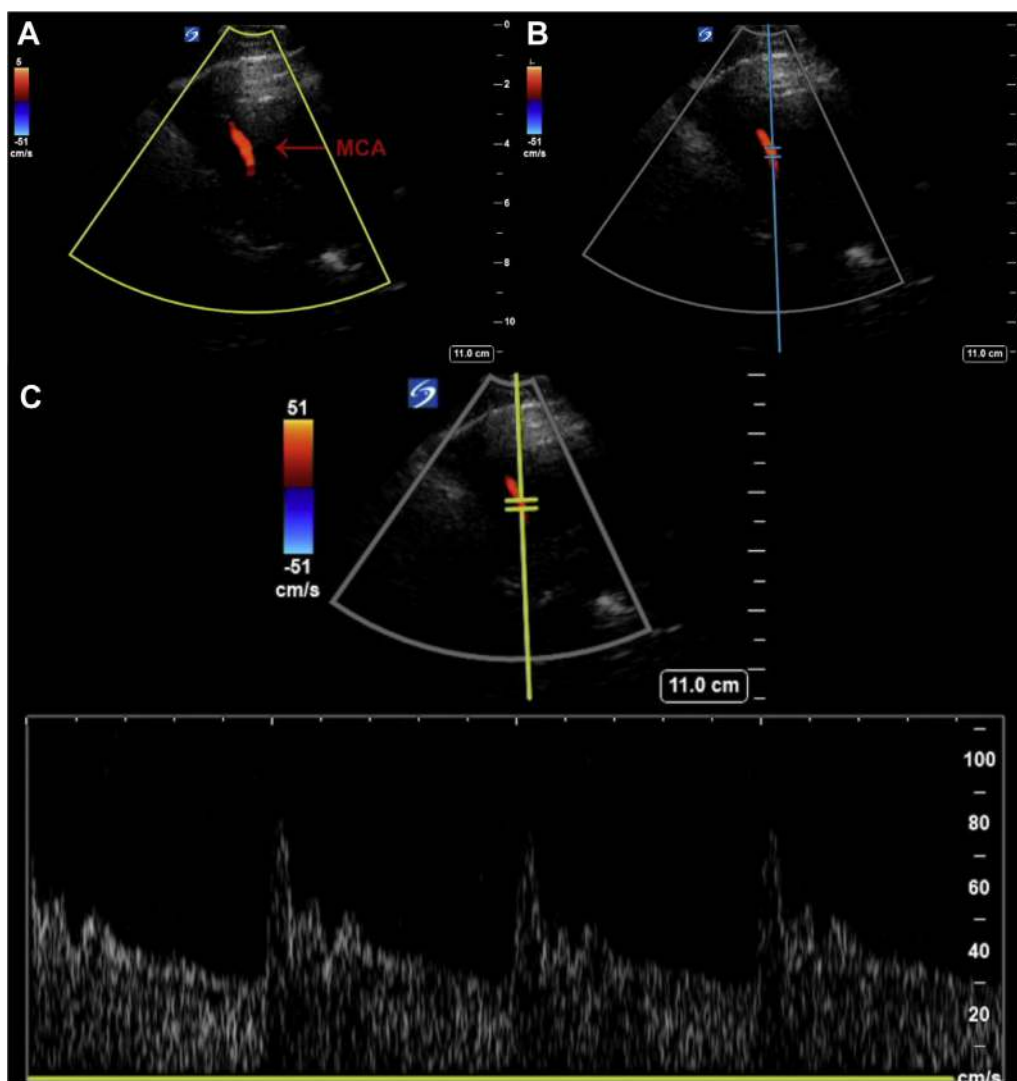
A-C, Color Doppler interrogation of the MCA. A, Locating the MCA with color Doppler, anterior (left of screen) of the midbrain. B, Interrogating the MCA with pulsed-wave Doppler. C, Resulting pulsed-wave Doppler tracing showing a steep systolic upstroke with a stepwise deceleration during diastole. MCA = middle cerebral artery.
